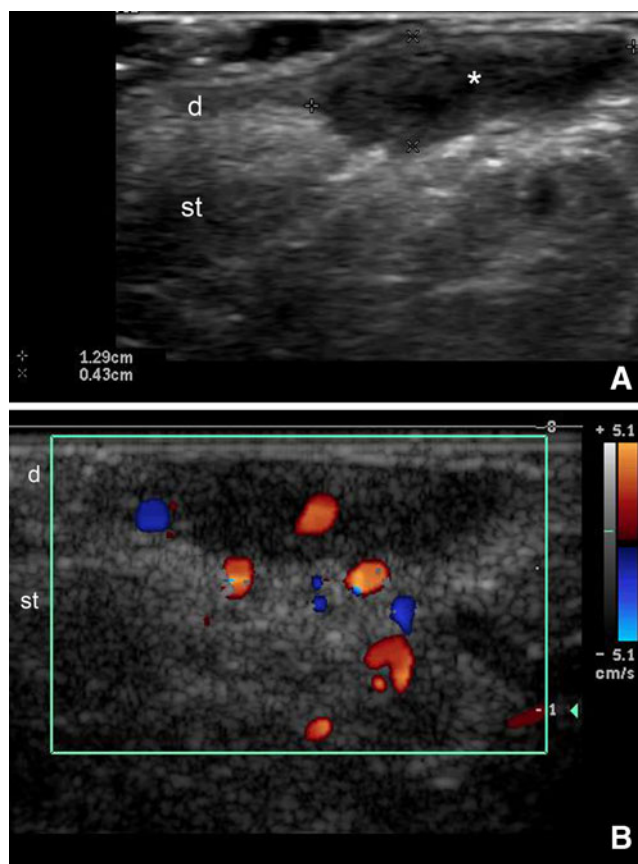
(A, B) Hidradenitis suppurativa. A Ultrasound (transverse axis) shows an hypoechoic dermal fluid collection (*asterisk*, between markers). B Color Doppler ultrasound (transverse axis) demonstrates increased blood flow surrounding the collection. Abbreviations: *d* dermis, *st* subcutaneous tissue
